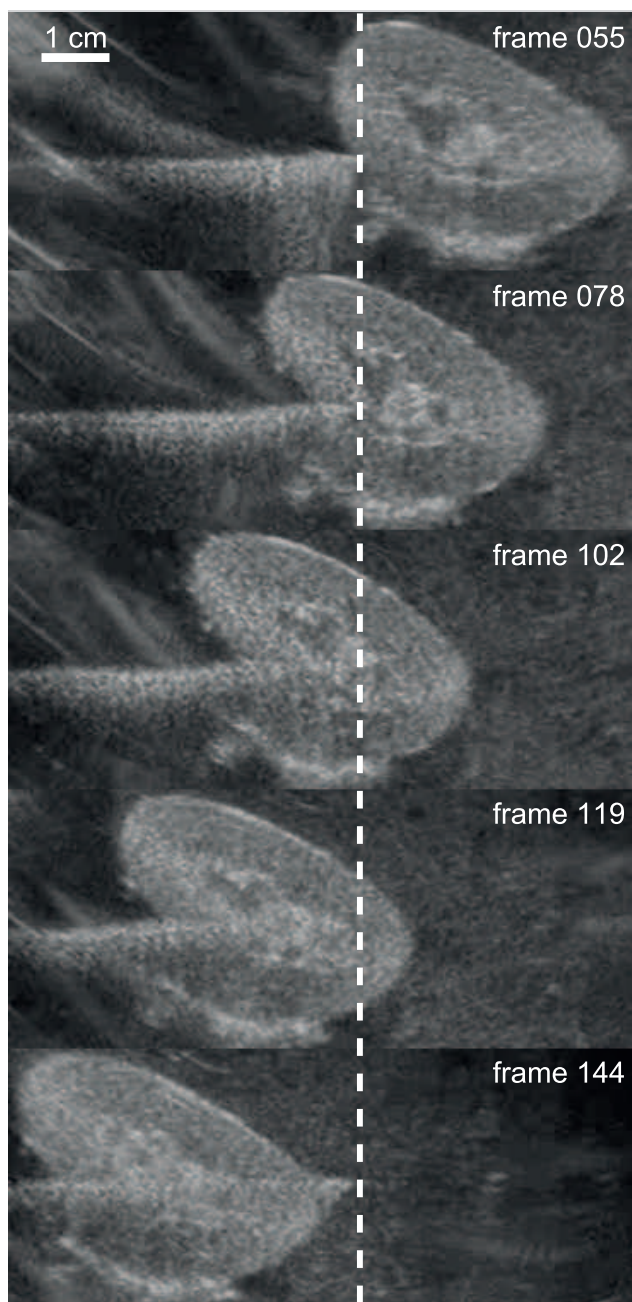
Sequence of ultrasound frames corresponding to the positions highlighted in Fig. 7.8. The dashed line represents the location of the needle tip.
